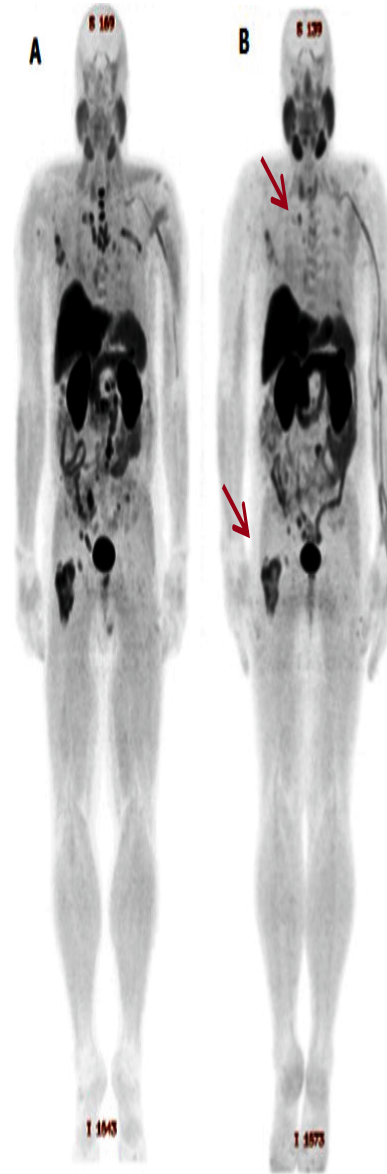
TEP-FCH avant traitement par acétate d'abiratéron (A) du patient porteur d'un cancer de la prostate métastatique résistant à la castration osseux et ganglionnaires (patient 3). La TEP à 6 semaines (B) est en faveur bonne réponse thérapeutique devant la nette diminution de l'hypermétabolisme des lésions initiales notamment à l'étage thoracique, sans apparition de nouvelles lésions ($\Delta\text{SUV}_{\text{max}} = -59.8\%$). Après 12 semaines de traitement, les douleurs et la scintigraphie osseuse était stable. L'évolution du taux de PSA était en faveur d'une réponse partielle
